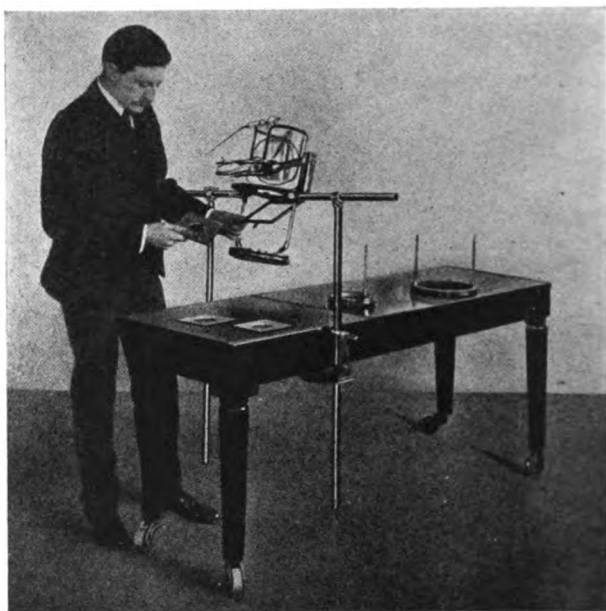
Röntgen radiographic table, lead-glass shield around *x-ray* tube (Röntgen Manufacturing Company).
